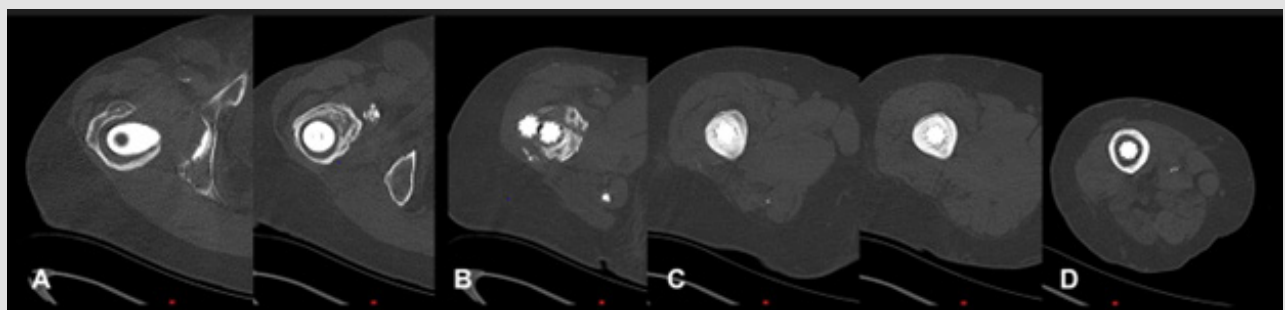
Transverse sections of a computed tomography with the broken implant.
